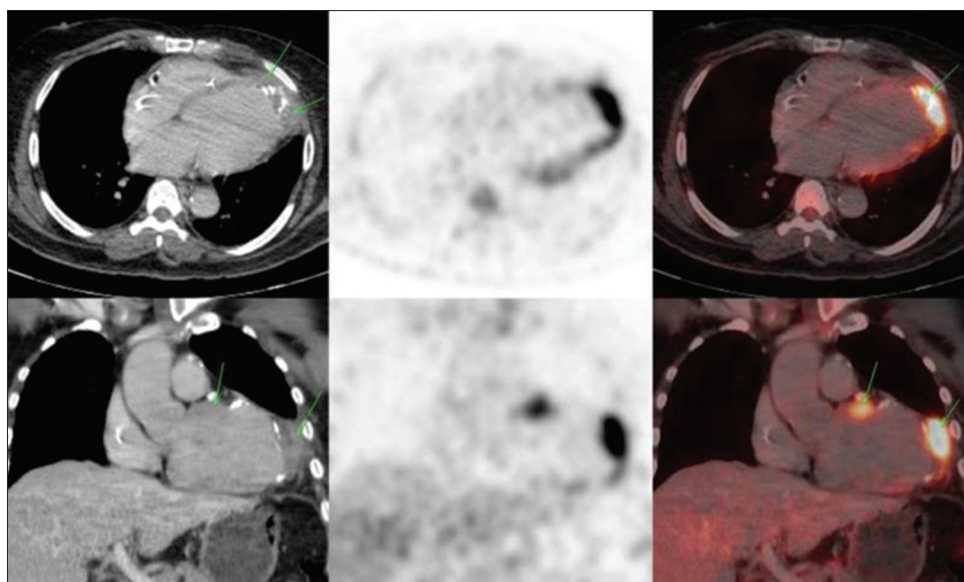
Axial and coronal sections of <sup>18</sup>F-fluorodeoxyglucose positron emission tomography with contrast-enhanced computed tomography image showing intense diffuse abnormal <sup>18</sup>F-fluorodeoxyglucose uptake in the region of the left ventricular apex where the autologous pericardial patch repair for left ventricular aneurysm was done. Physiological fluorodeoxyglucose uptake in the base of the left ventricular myocardium is also seen
